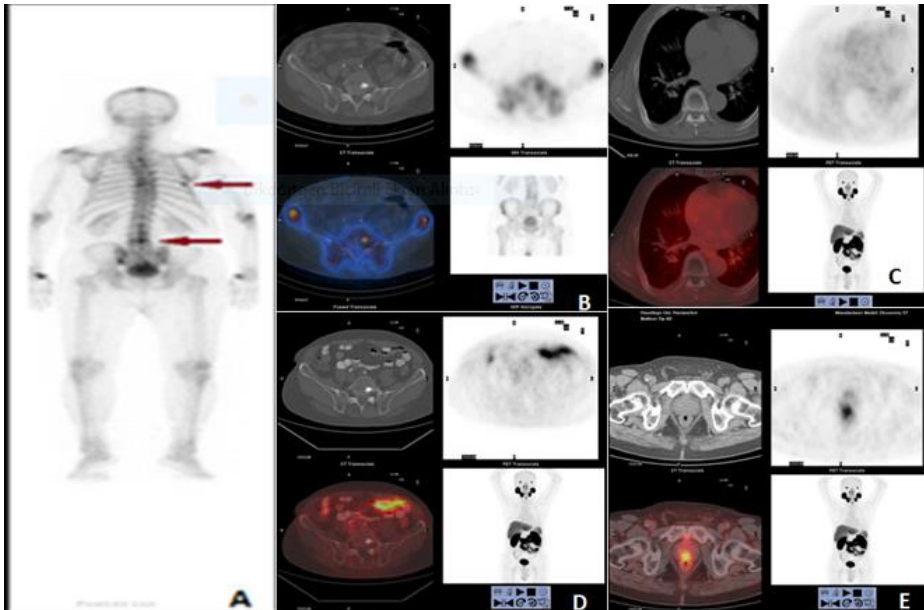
(GS: 7, PSA: 8.3) bone scintigraphy (A), SPECT CT (B), and PET-CT (C, D and E) images. Bone scintigraphy shows involvement in the sclerotic lesion in the left 7th rib and L5 vertebra. On PET images, only prostate involvement was detected, no involvement was observed in the areas described in bone scintigraphy, and possible bone metastases were detected. has been ruled out.
